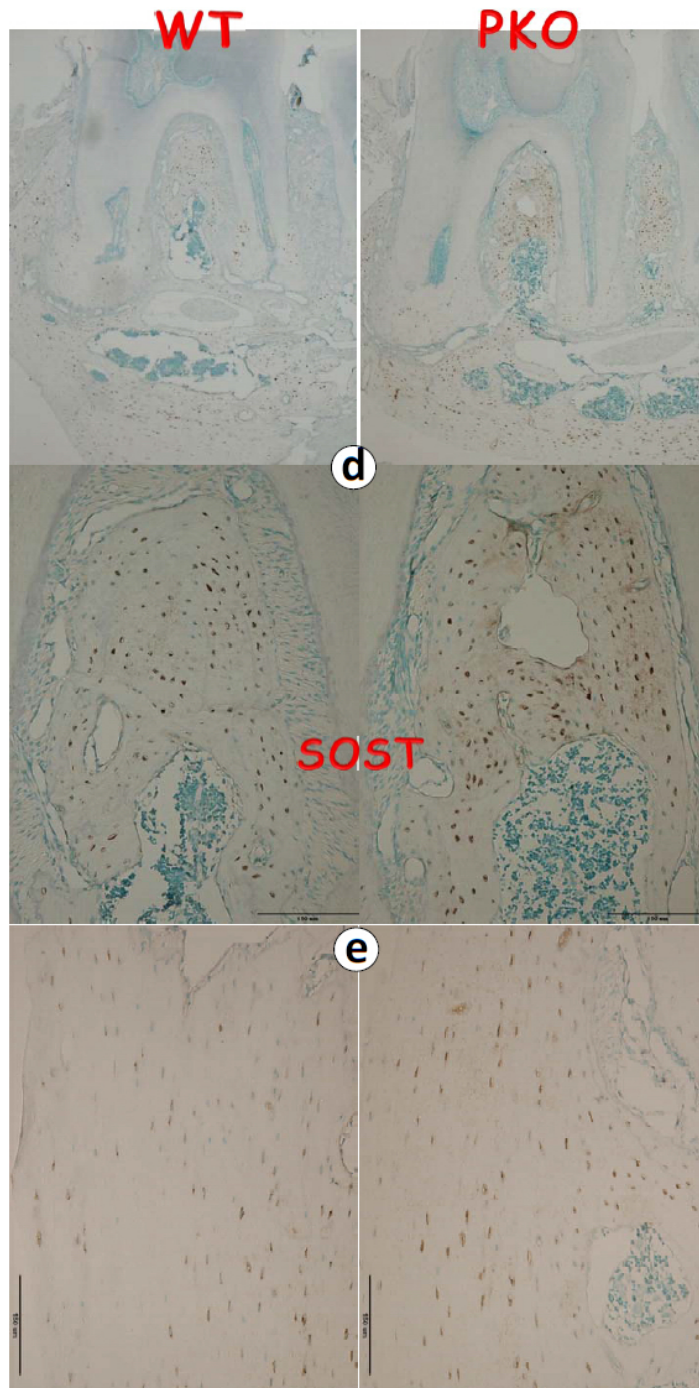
S2 Fig. S2 *Deletion of periostin (PKO) lead to local changes of osteocytes (Ocys) and a sharp increase in SOST in the PKO jaw bone but not in long bone.*(a) Representative radiographs revealed bone loss in PKO alveolar bone (*right*); (b) Acid
